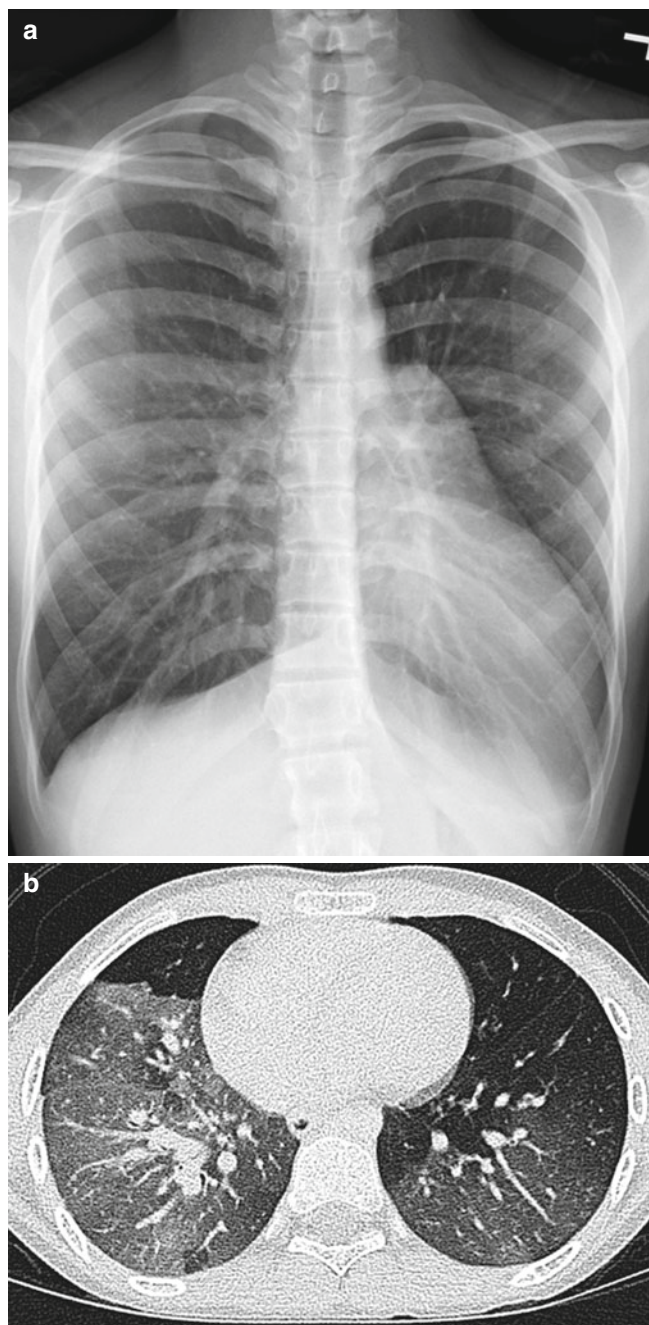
Bronchiolitis obliterans (Swyer–James–Macleod syndrome) in a 6-year-old girl with multiple viral pneumonias. (a) Frontal chest radiograph shows hyperlucent left lung with decreased lung volume and underlying pulmonary vessels in comparison to the right lung. (b) Axial lung window CT image demonstrates accentuated hyperlucent oligemic segments of lung, worse on the left side than the right side
